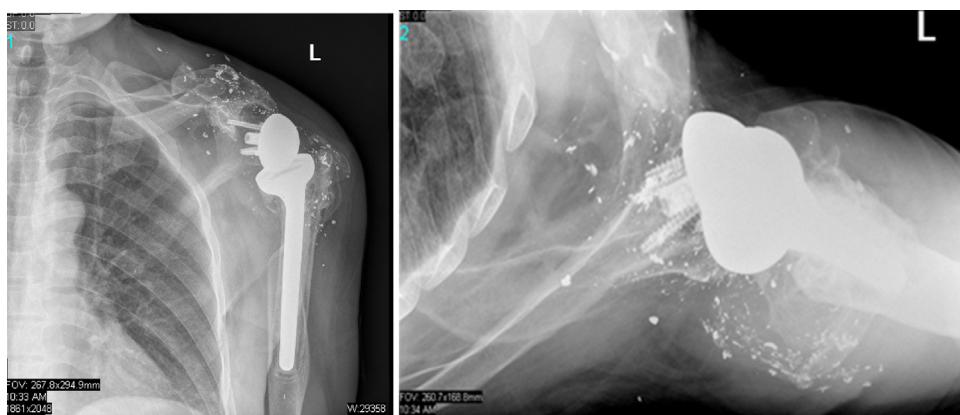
Postoperative radiograph in AP and axillary views, showing the implant components.
